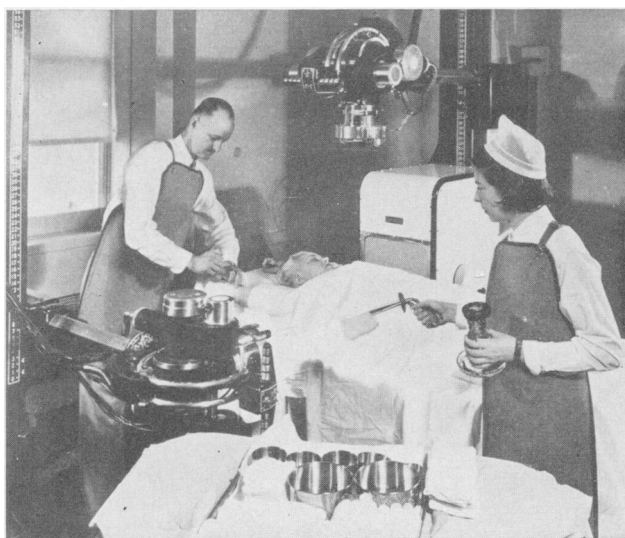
Patient lying on radiographic table for angiocardiographic study. Note X-ray tubes for anterior-posterior and lateral filming.
